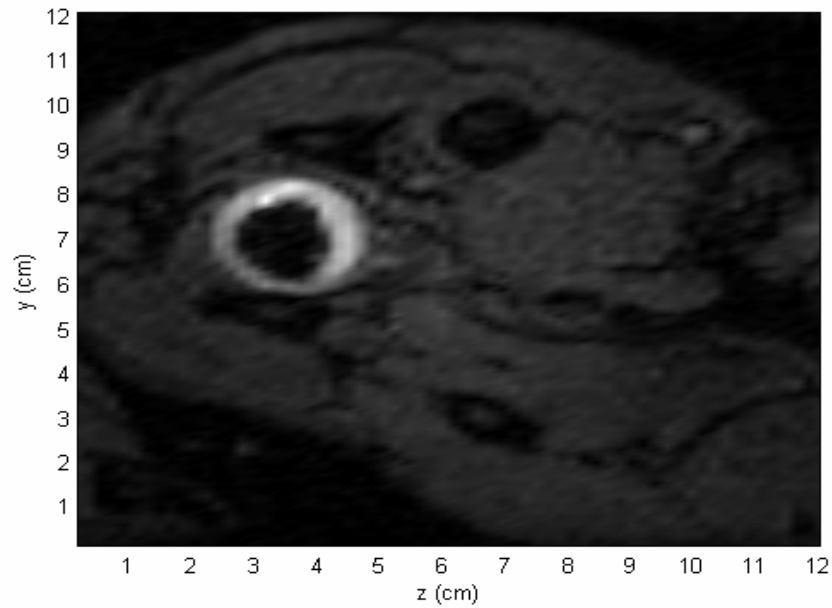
(a) MR image of the axial view of the canine prostate, showing the location of the ultrasound array, canine prostate and water bolus. (b) In the preliminary canine prostate hyperthermia experiments, the agreement of MR temperature measurements and the reference indicates the potential of intracavitary ultrasound hyperthermia treatment for human prostate cancer.
